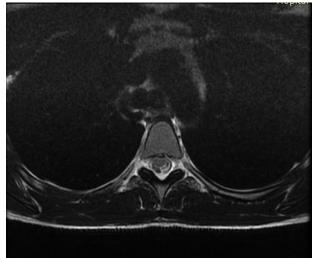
Spinal MRI: axial T2 section passing through T4 showing the double spinal cord appearance linked to CSF flow artifacts, a priori eliminating an arachnoid cyst
